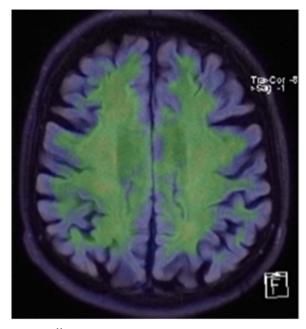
Negative <sup>11</sup>C –PIB-PET-MR image from a patient with symptoms suggesting Alzheimer disease demonstrating a distinctive pattern of moderate degree non-specific tracer uptake within the white matter but not any cortical binding. The FLAIR-T2-weighted MR image demonstrates bilateral frontoparietal sulcal widening indicating cortical volume loss.
